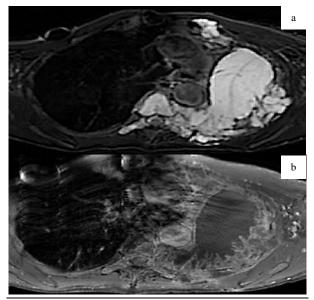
a: T2-weighted axial magnetic resonance imaging (MRI) demonstrated extensive multiseptated mass involving both left pleura, lung, and adjacent vertebra. They appear in high signal on T2-weighted sequences due to their mucin composition; b: Contrast-enhanced T1-weighted axial magnetic resonance imaging (MRI) exhibiting areas of slight enhancement within the lesions as usually seen in mucinous tumors
